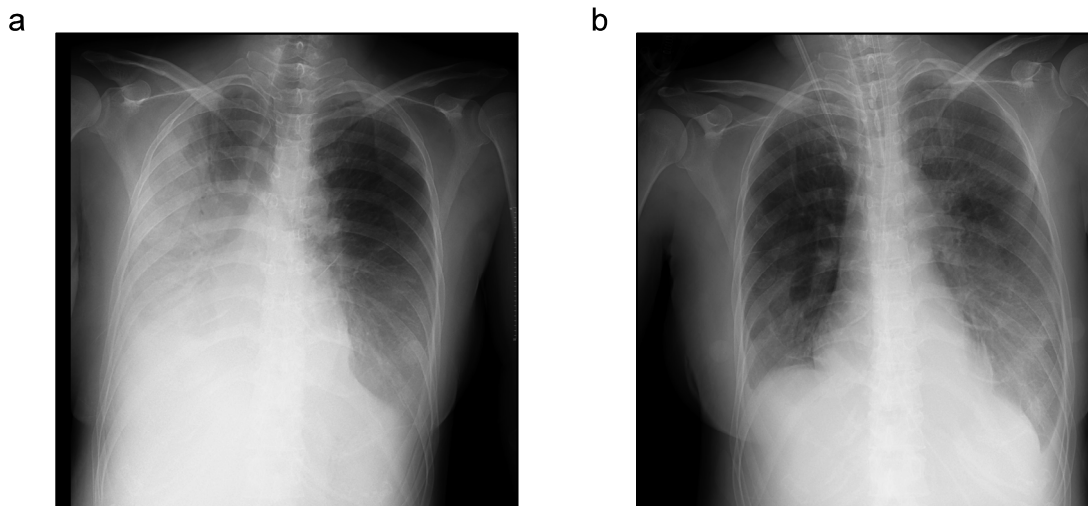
Chest radiographs. (a) ICU admission: bilateral pleural effusion, right predominant, with reduced aeration. (b) ICU day 1, the day after iNO initiation and pleural drainage : improved aeration and decreased effusion were observed.
